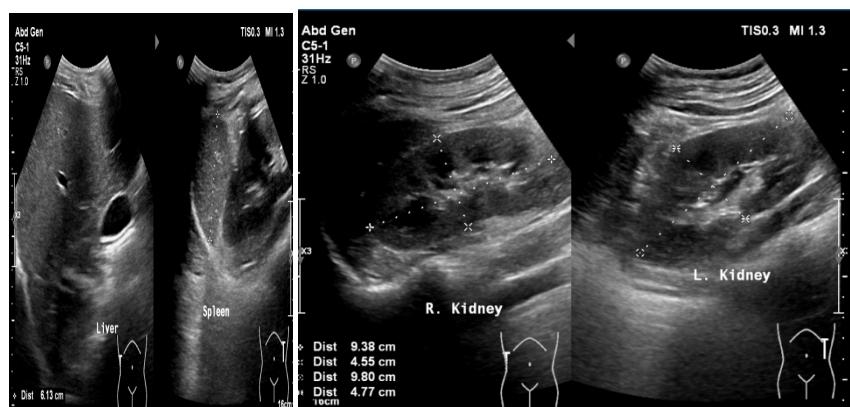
Liver and kidney ultrasound
